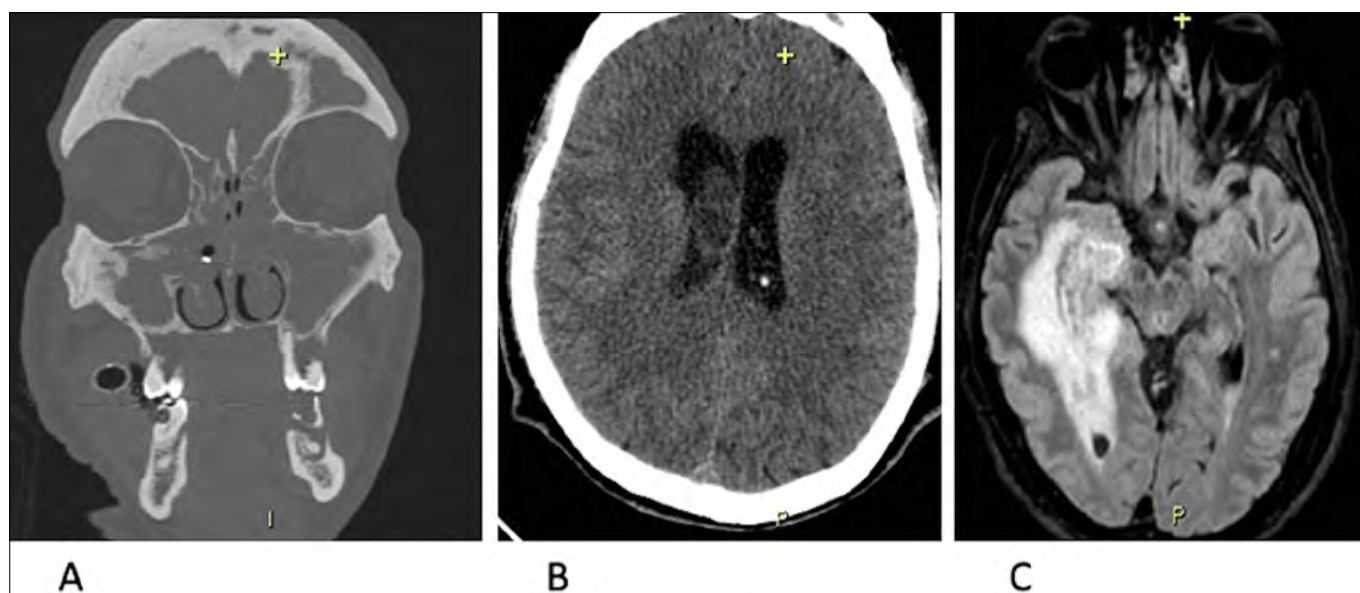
(A-B) CT with acute sinusitis (frontal, ethmoid, maxillary sinus; no sphenoid sinus involvement) and ventricular empyema; (C) MRI with brain abscess and edema.
